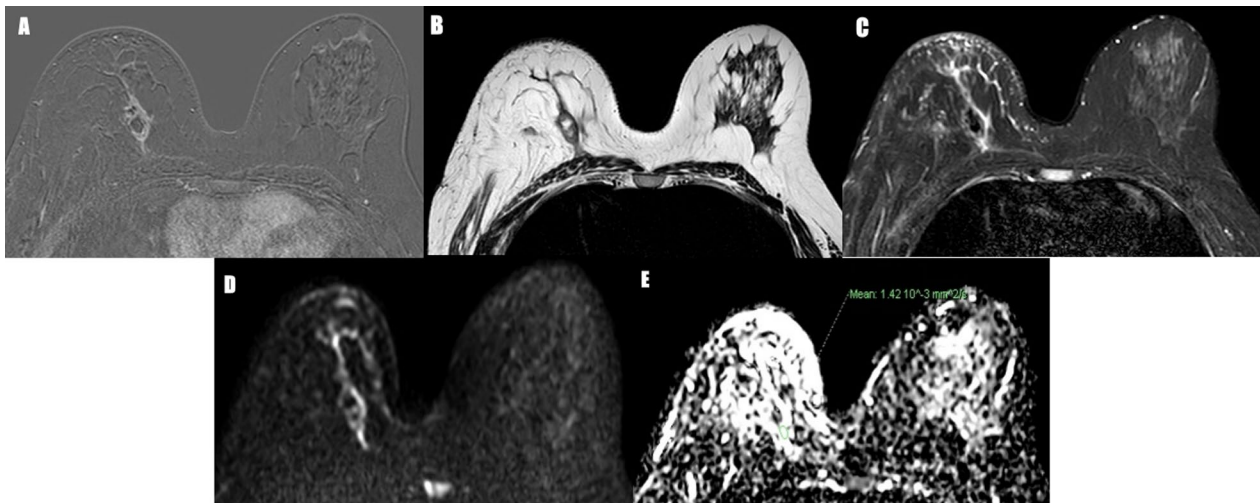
45 years old female with a history of right breast mastectomy with latissimus dorsi flap reconstruction 2 months ago, complained of right breast pain and hardness, ultrasound was done revealing an intact flap with marked edema and shadowing at the operative bed, MRI was done, and revealed: A STIR image: The right breast shows minimal subcutaneous and interstitial edema with a posteriorly located lesion of low SI. B T2WI: The right breast post-operative lesion of high SI with a medially related area of low SI. C Subtracted image: The right breast post-operative lesion shows smooth marginal enhancement with non-enhancing low SI at the central part of it. D DWI: The right breast lesion shows free diffusion. E ADC map: The right breast lesion shows a high ADC value = 1.42×10^{-3} mm^2/s . Pathologically proved to be traumatic fat necrosis. No malignancy
